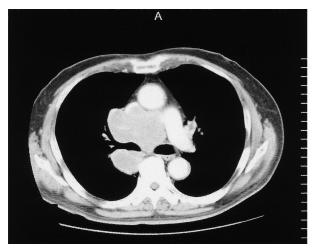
Chest CT showing the mediastinal mass compressing superior vena cava, trachea, and main bronchi. Scale divisions represent 1 cm each.
